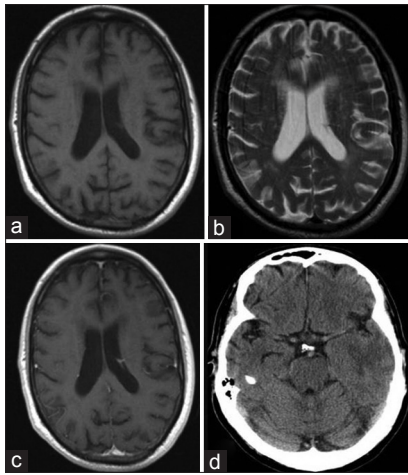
Preoperative (a) magnetic resonance imaging (axial view) T1-weighted image. (b) T2-weighted axial image. (c) Postgadolinium contrast enhanced MRI image. (d) Noncontrast computed tomography scan of the brain showing an intra-axial heterogeneously enhancing mass in the left temporoparietal region
